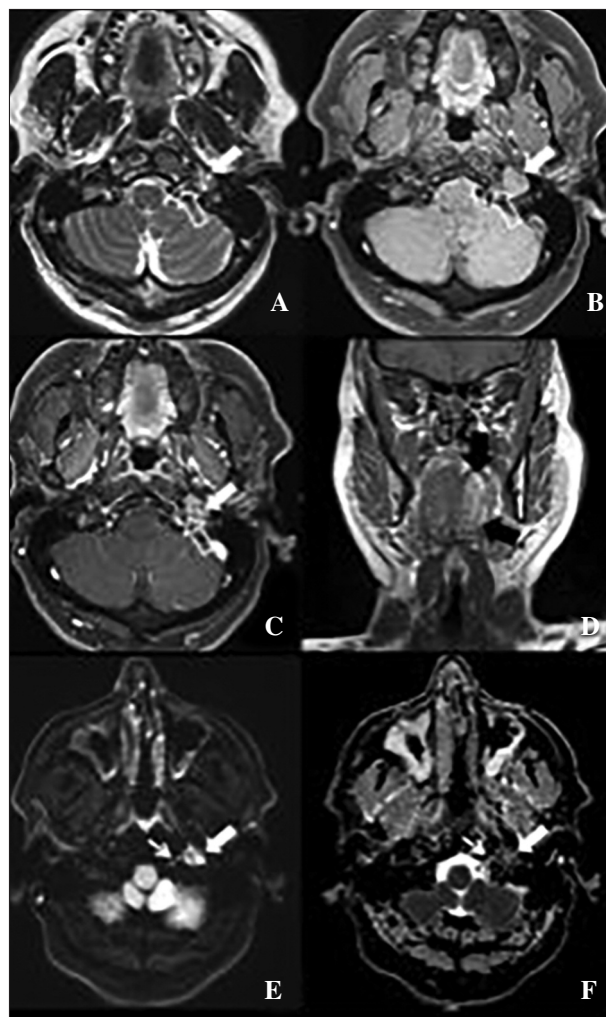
Cranial MRI images of the patient. A: A T2-weighted image in the axial plane shows a hyperintense lesion (thick white arrow) on the left jugular foramen, obstructing the external orifice of the left hypoglossal canal (open arrow). B–C: Pre and postcontrast fat saturated axial plane T1-weighted images show a highly vascular lesion (thick white arrow). D: A coronal plane T2-weighted image shows denervation atrophy of the left lingular muscles (thick black arrow). E–F: A diffusion-weighted image and the ADC map show diffusion restriction of the lesion (thick white arrow) along with cytotoxic edema of the left hypoglossal nerve (thin white arrow) due to compression
